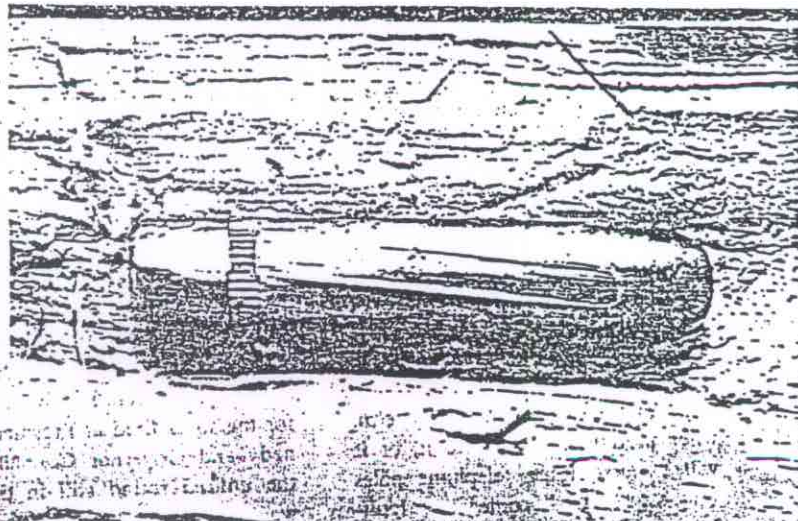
UNDEFORMED BULLETS: 6A: X-ray of a bullet which has traversed 25 inches of a block of the toughest elm wood, before being stopped. This bullet is undeformed. Nichols has shown that this bullet can penetrate 47 inches of Ponderosa pine boards without deforming. (X-ray courtesy of Dr. David Follert of Squier Urological X-Ray Dept.)
